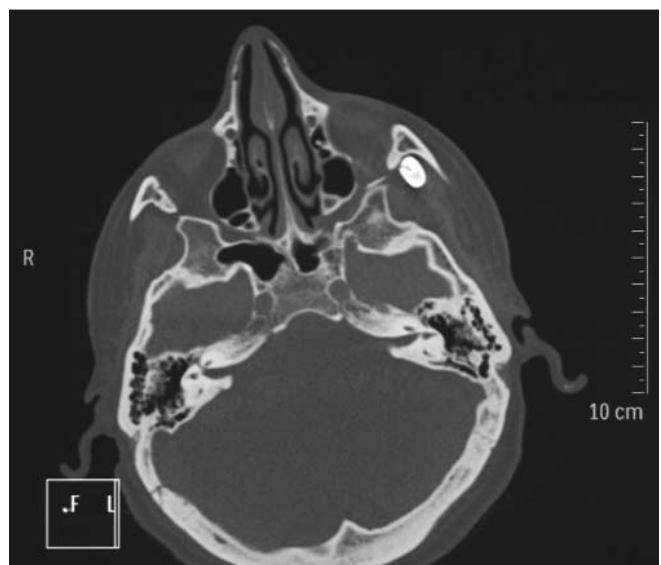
An axial preoperative CT scan allows to assess the precise relationships between the tooth and the anatomical structures of the infratemporal fossa
